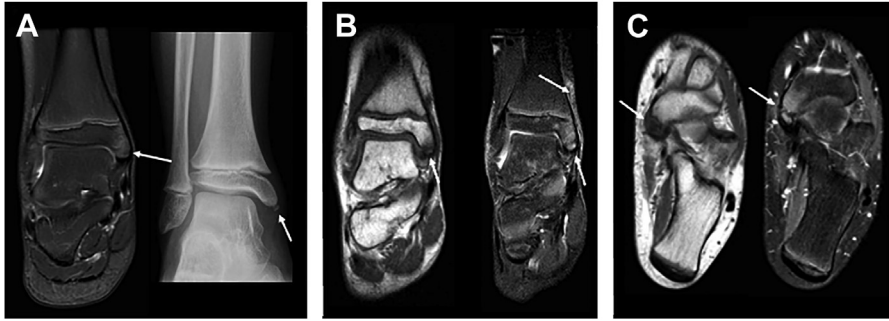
SOC: normal x overload. (A) Normal aspect of the secondary ossifying center of the medial malleolus in a coronal T2WFS MR image and frontal digital radiography of an 8-year-old boy (arrows). (B) A 7-year-old girl with medial ankle pain presenting with bone marrow (lower arrows) and overlying soft tissue edema that extends to the subcutaneous planes (upper arrow), suggestive of mechanical apophysitis. (C) MR images of a 9-year-old girl's foot depicting bone marrow edema at the SOC and at the navicular bone (arrow) (apophysitis).
